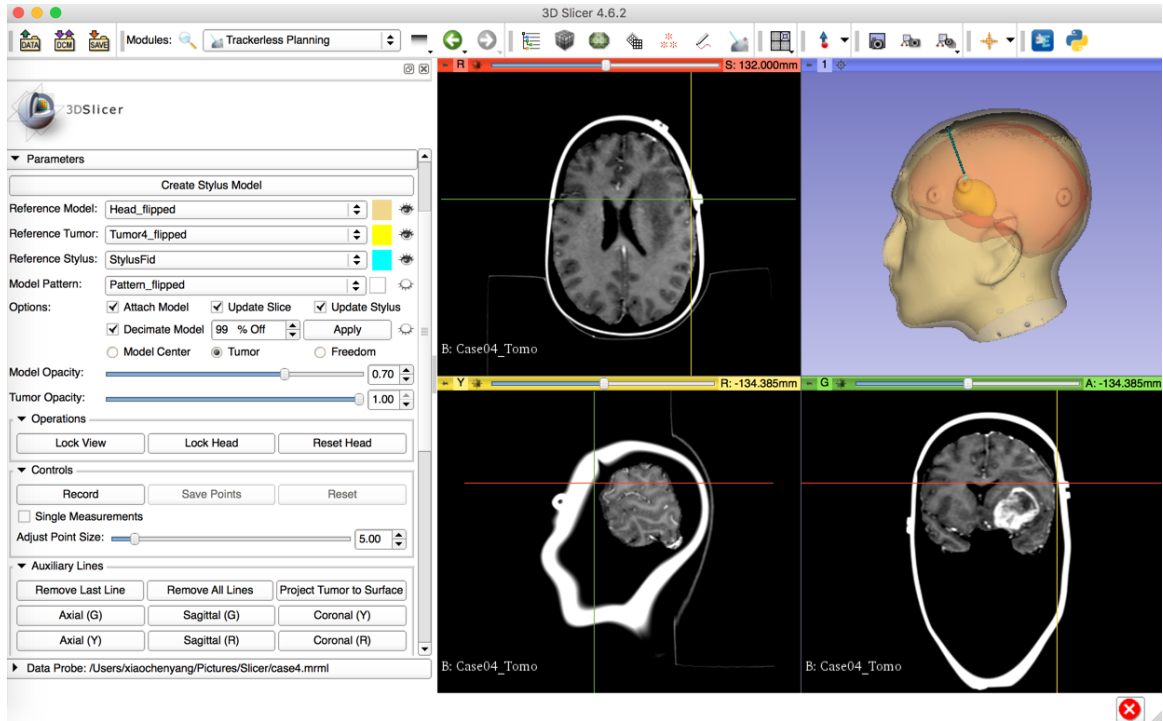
Overview of the 'trackerless' surgical planning extension. The virtual stylus and traditional three-panel display of the MRI mirrors the display in the conventional approach.
